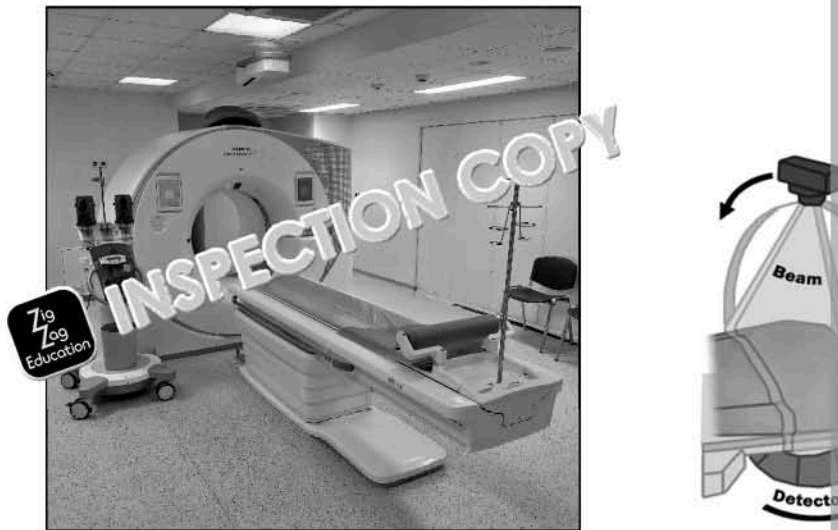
The basic structure of a CT scanner.
